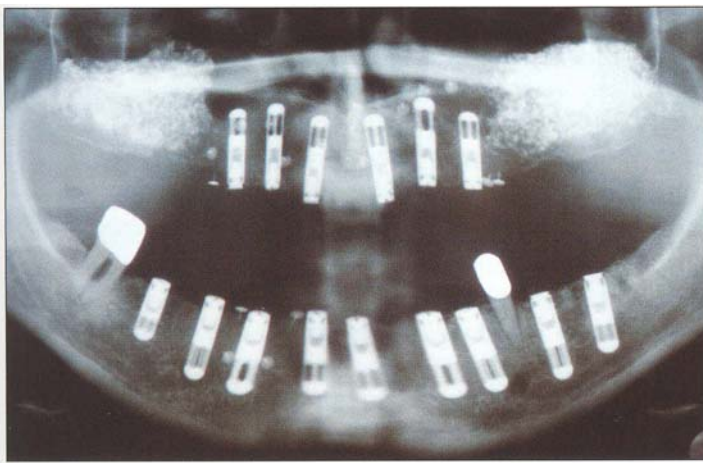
7b Panoramic radiograph taken 9 months after the two-stage sinus grafting with Interpore 200 on both sides and placement of seven 4-mm-diameter titanium plasma-sprayed cylinder implants in the alveolar bone.
